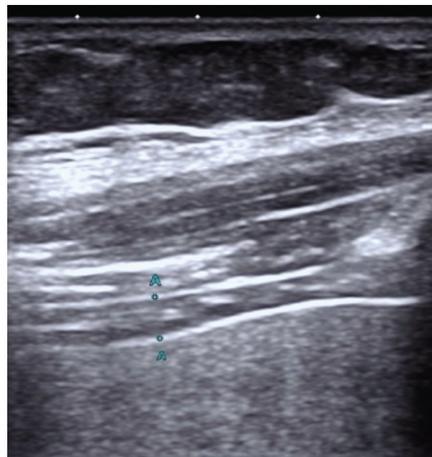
Ultrasound measurement of diaphragmatic thickness.
